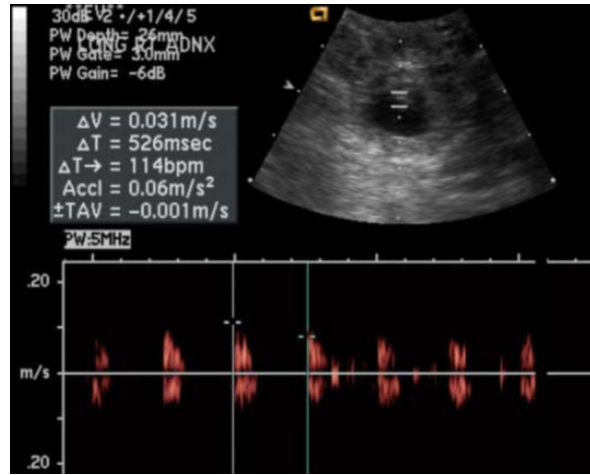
Transvaginal ultrasound showing cardiac activity at 114 BPM in the ectopic pregnancy.
